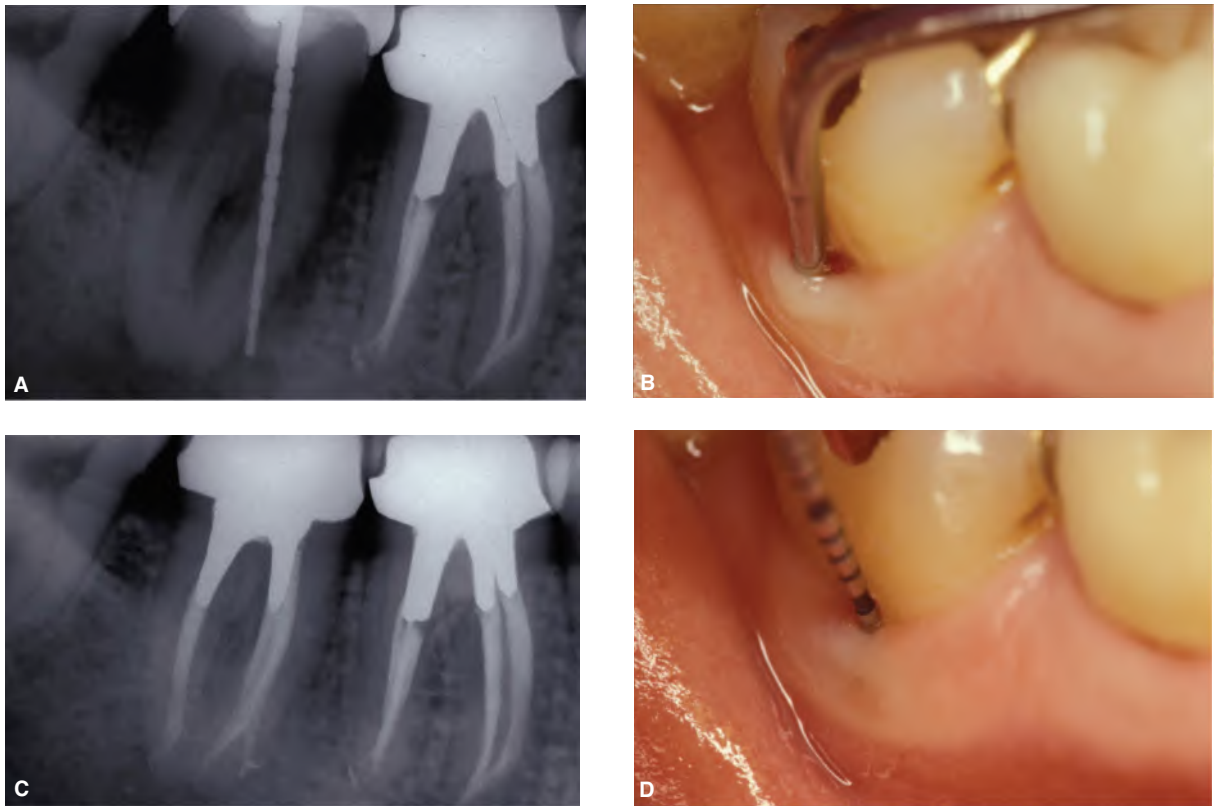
Primary endodontic disease in a mandibular second molar with necrotic pulp. A. Preoperative radiograph showing periradicular radiolucency associated with the affected tooth. B. Clinically, a deep narrow buccal periodontal defect can be probed. C. One year after root canal treatment, resolution of the periradicular bony radiolucency is evident. D. Clinically, the buccal defect healed and probing is normal. (Courtesy of Dr. Jean-Yves Cochet, Paris, France.)
